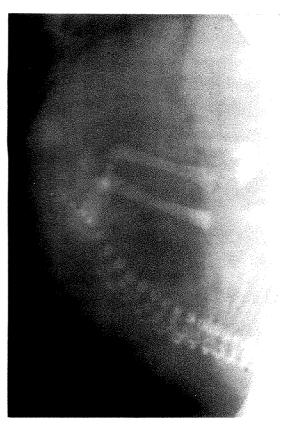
The placenta is clearly seen as a crescentic soft tissue opacity implanted in the fundus posteriorly (the mother is facing to the observer's left). The fetal lumbar spine could easily be measured on such a roentgenogram as an aid to the prediction of crown-heel length. Distal femoral epiphyseal ossification centers are not seen.
